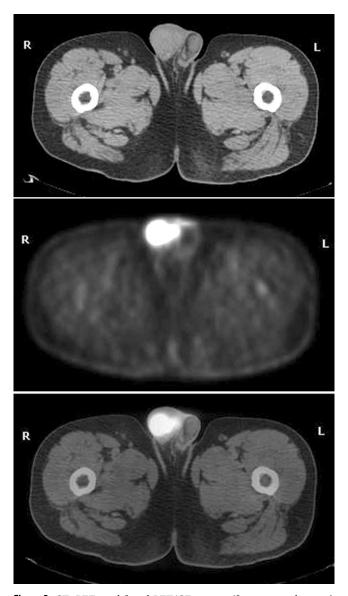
CT, PET, and fused PET/CT images (from top to bottom) demonstrated very intense uptake with a maximum standardized uptake value (SUVmax) of 17 in the right testicular mass.
